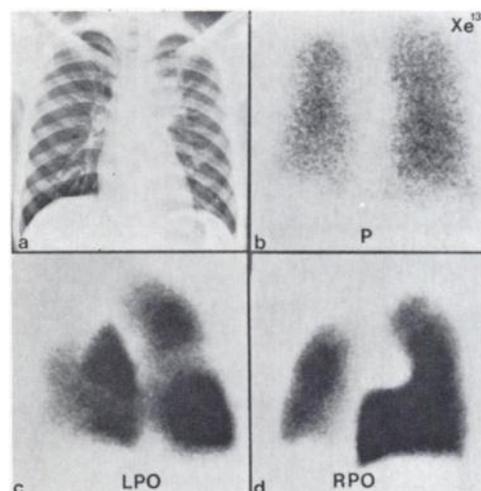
Case 1. (a) Chest radiograph showing left paratracheal mass. (b) Posterior Xe-133 "first-breath" scan showing relatively uniform air distribution other than mild volume loss on left. No delay was seen in washout images. (c, d) Tc-MAA scans show unmatched perfusion defects.
